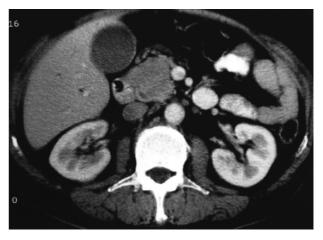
A 3.5×3 -cm well-circumscribed tumor is located at the pancreatic head by computed tomography following contrast enhancement.
